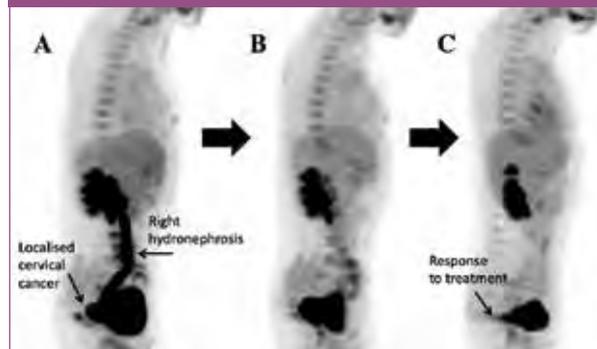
a, b, c. Serial PET CT scans of locally advanced cervical cancer, during and after completion of concurrent chemoradiotherapy, showing resolution of the right hydronephrosis (caused by local mass effect of the cervical cancer itself) and response of the primary tumour to the therapies with loss of FDG avidity
